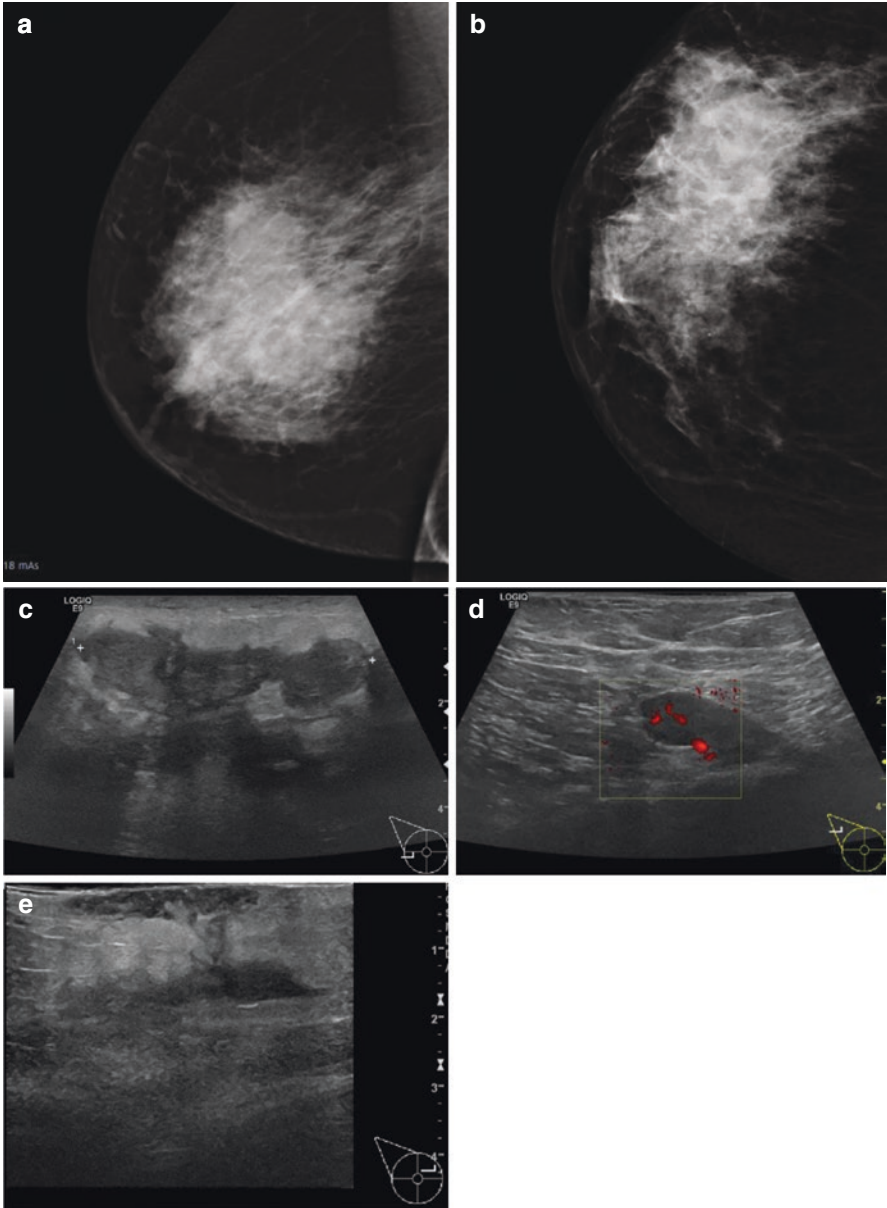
(a, b) A 51-year-old woman with a 45-mm firm mass in the right breast with nipple retraction, peau d'orange, and suspicious adenopathy thought to be inflammatory carcinoma. Mammograms show an ill-defined 47-mm mass in the right breast. (c) Ultrasound shows a 55-mm ill-defined mass with surrounding inflammatory change and dermal thickening. (d) There are also abnormal right axillary nodes. (e) There was subsequent development of an inflammatory mass with a sinus tract extending into the skin. Core biopsy of the right breast and axilla shows granulomatous mastitis with negative screens for sarcoidosis and tuberculosis
